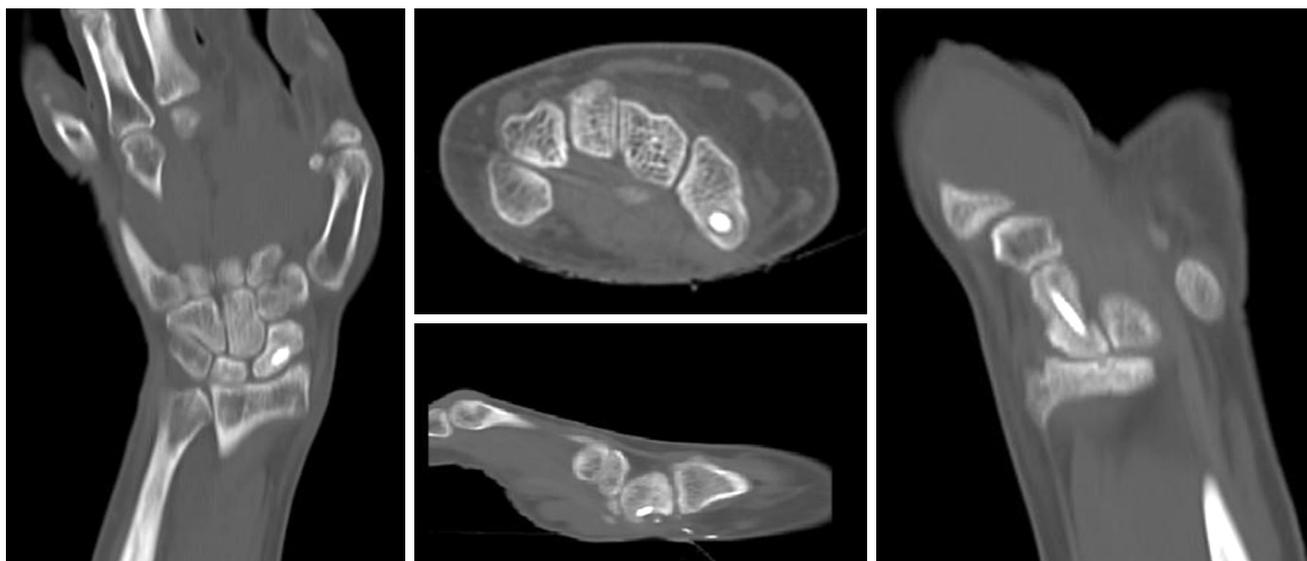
Union on computed tomography scans.
